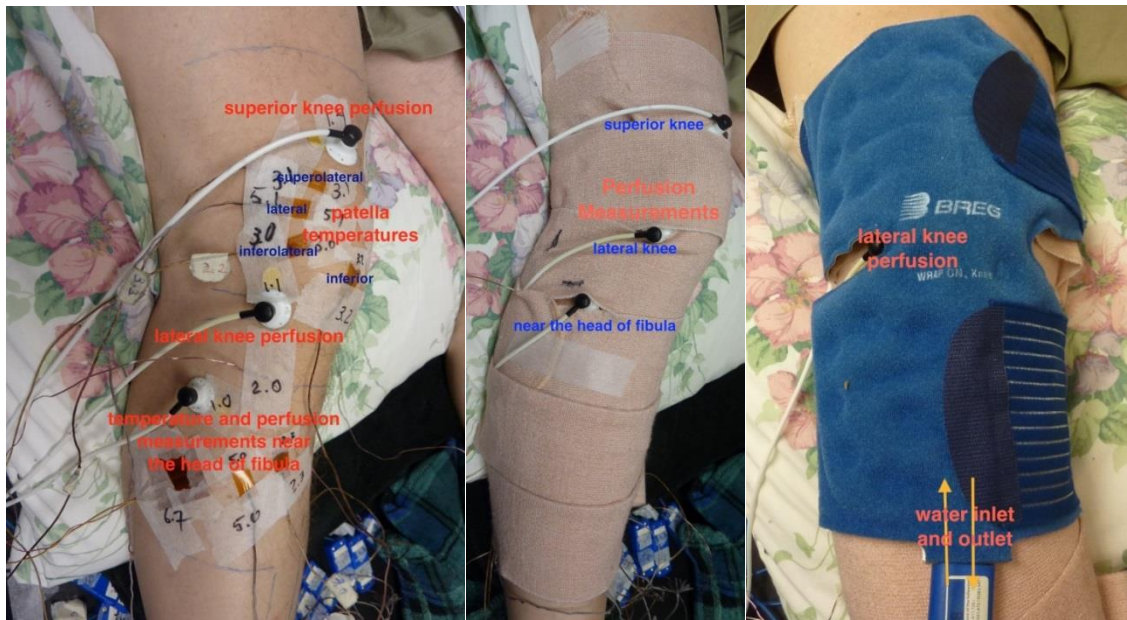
Instrumentation of a subject for a CTU tested on the right knee. The view is from the ventral aspect. (a) Sensors applied to the skin, including six smaller rectangular thermocouples, one larger square heat flux gauge, and three fiber optic probes for laser Doppler measurements. Numbers written on mounting tape indicate connection junctions of lead wires to the DAQ. (b) The same area after a thermal insulation barrier consisting of a single layer of ACE bandage wrap has been applied with no elastic stretching. (c) A Breg Polar Care cooling bladder positioned over the thermal barrier.
